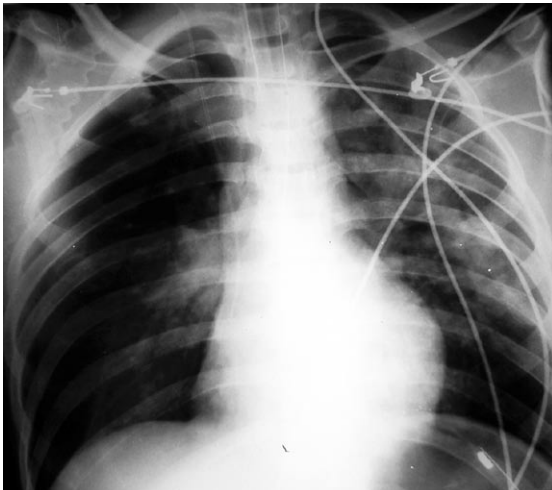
Chest radiograph shows clearing alveolar opacities consistent with resolution of pulmonary oedema.
